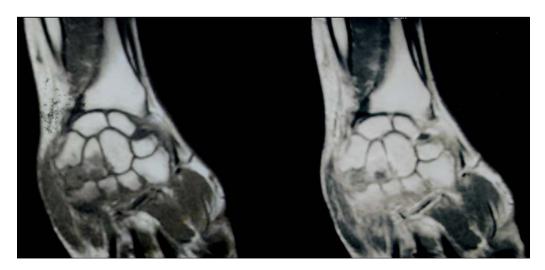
MRI: hypo-intense lesion on T1 images of the unciform process and the distal hamate bone. Heterogeneous uptake of contrast after injection of gadolinium.
